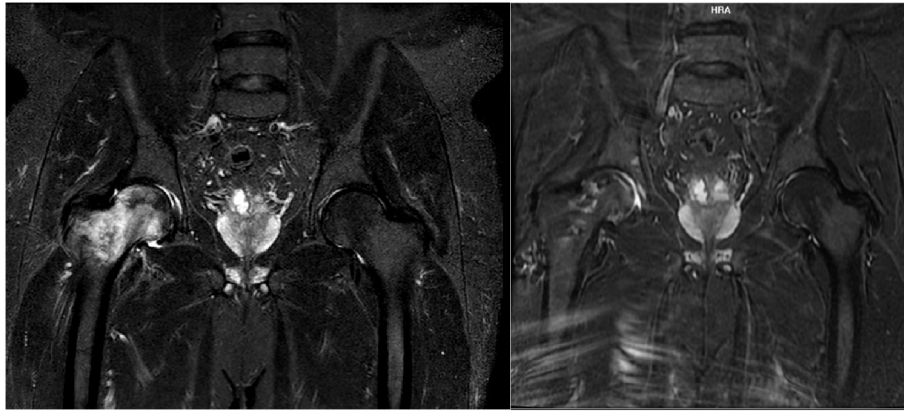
On the left STIR MRI weighted coronal image of the hips preoperatively and on the right 3 months postoperatively.
